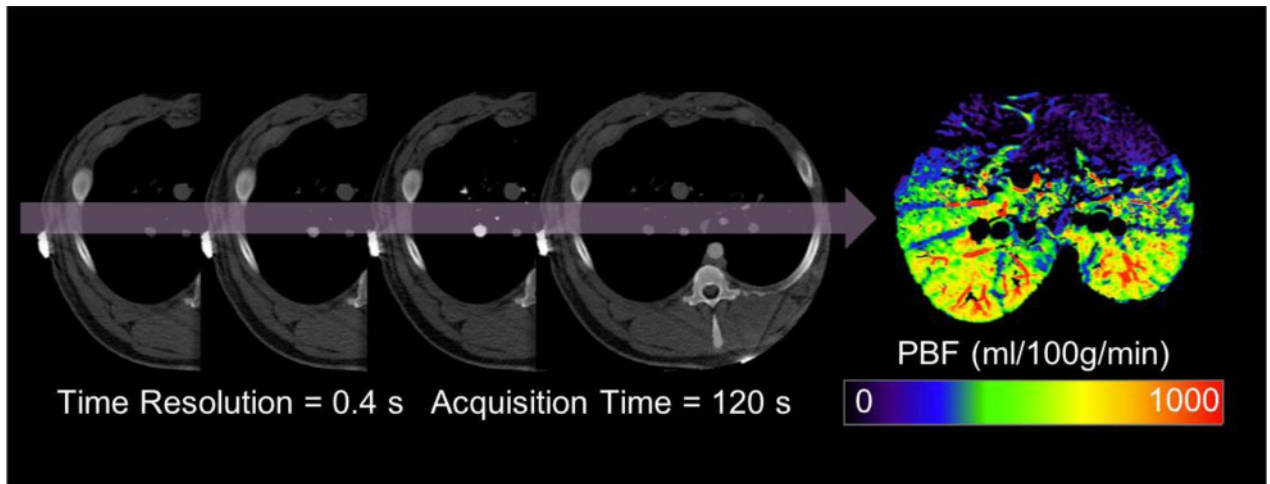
First-pass dynamic computed tomography perfusion. Pulmonary blood flow was calculated via deconvolution of time-attenuation data. Figure 4 can be viewed online in color at www.jcat.org.
